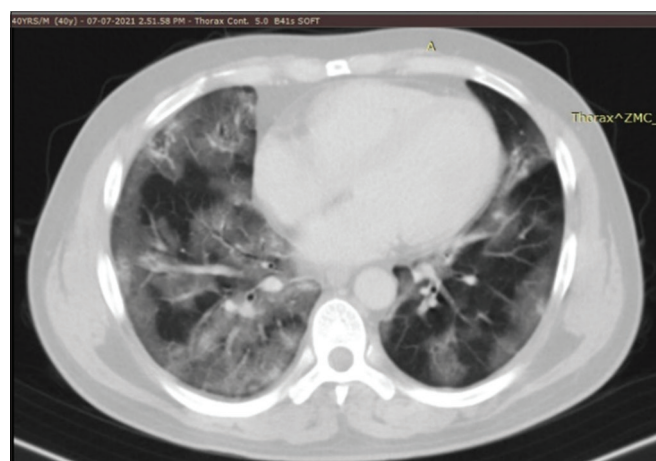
Baseline CT chest showed subpleural and peribronchial Ground glass opacity in all the case series where Chest CT was performed
